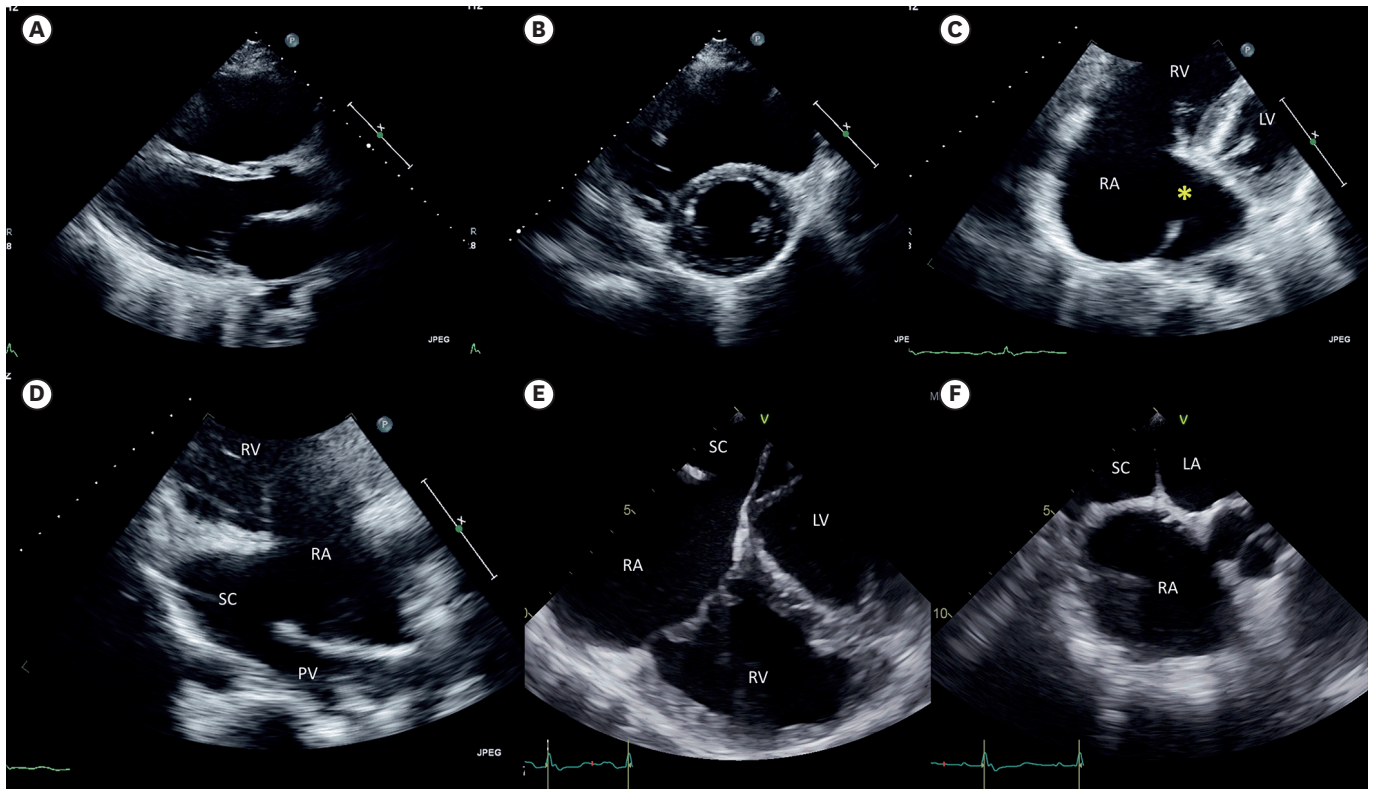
(A, B) Transthoracic echocardiography shows the RV and RA are enlarged. (C) Modified apical 4-chamber view with inferior tilting shows a large defect (yellow asterisk) mimicking primum ASD. (D) Apical 2-chamber view reveals the defect to be connected to a scimitar-shaped conduit (SC). (E, F) Transesophageal echocardiography shows SC drains into RA, coursing behind the interatrial groove. ASD: atrial septal defect, LV: left ventricle, RA: right atrium, RV: right ventricle, PV: pulmonary vein, SC: scimitar vein.
